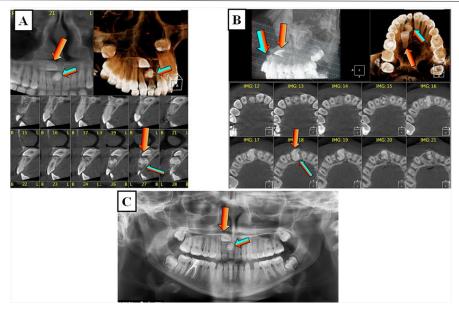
A–C: CBCT images (A, B) and a panoramic radiograph (C) of a patient with supernumerary teeth in the form of an odontoma (blue arrows), which caused the displacement and retention of tooth 11 (red arrows).
